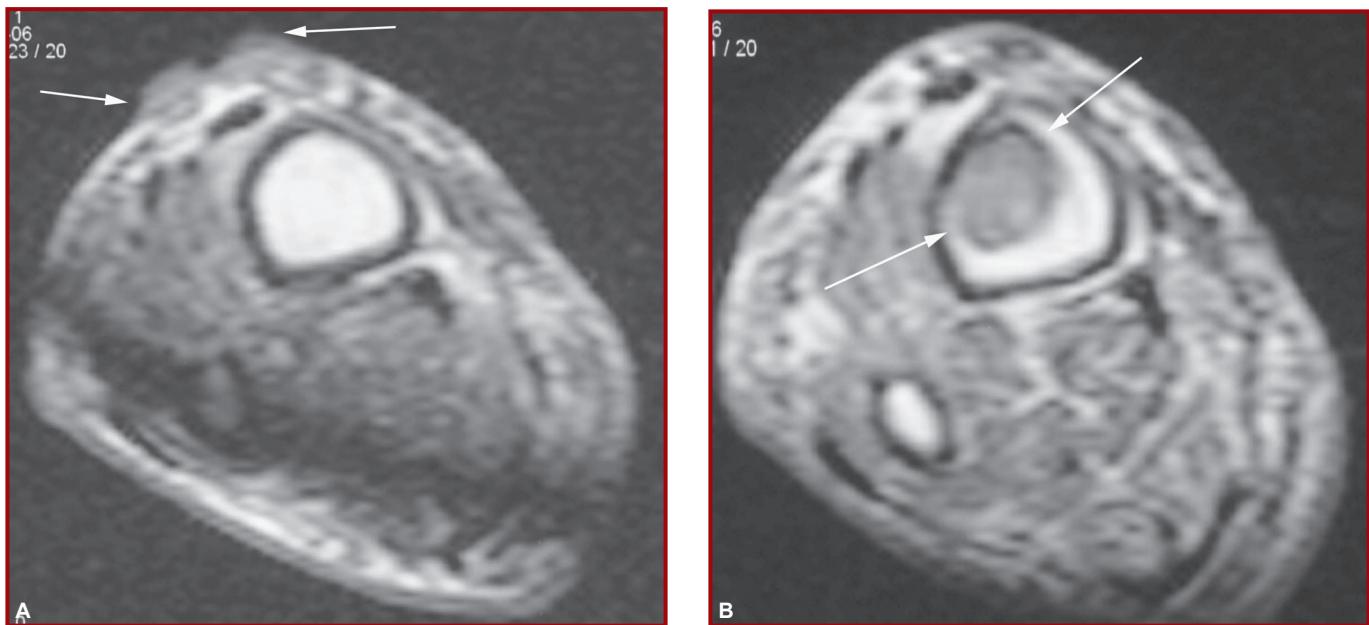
Transverse T1-weighted image following the administration of intravenous contrast media demonstrates contrast enhancement both A. in the cutaneous lesions (arrows) and B. lesion in the bone marrow (arrows)
